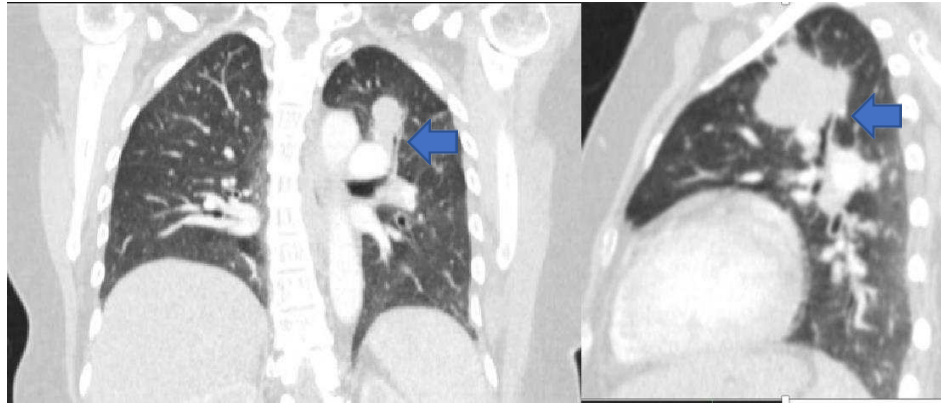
Female, 57 years with peripheral SCLC. Contrast enhanced chest CT coronal and sagittal section of lung window shows bronchial cutoff sign (+) (blue arrow)
